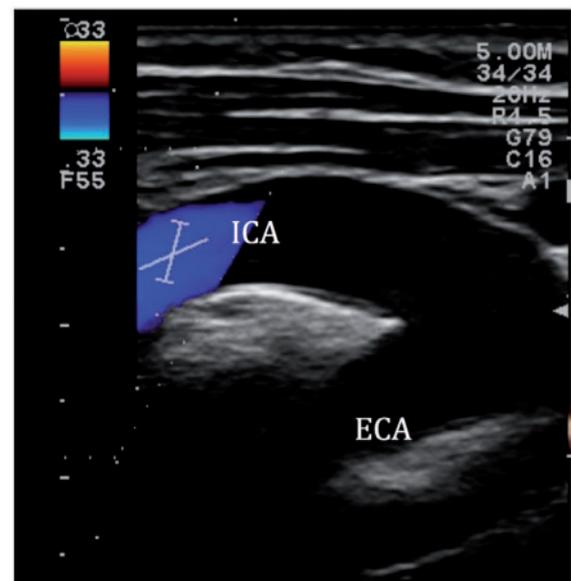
2D echo and colour Doppler flow imaging: carotid bifurcation.
